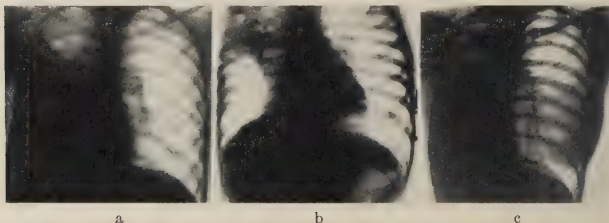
Roentgenogram of the lungs on admission, showing extensive involvement of the right lung and suspected pleural involvement. The mediastinal structures are considerably displaced to the right indicating shrinkage of the affected lung.
